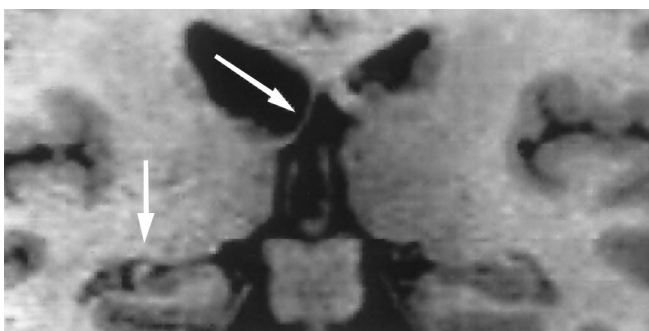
Representative example of MRI showing severe right hippocampal and fornix atrophy in a patient with right MTLE onset and pathologically proven MTS. The volumes of the right hippocampus (arrow) and fornix (arrow) in this patient were 2 SD below normal range, whereas the left-sided structures are normal.
